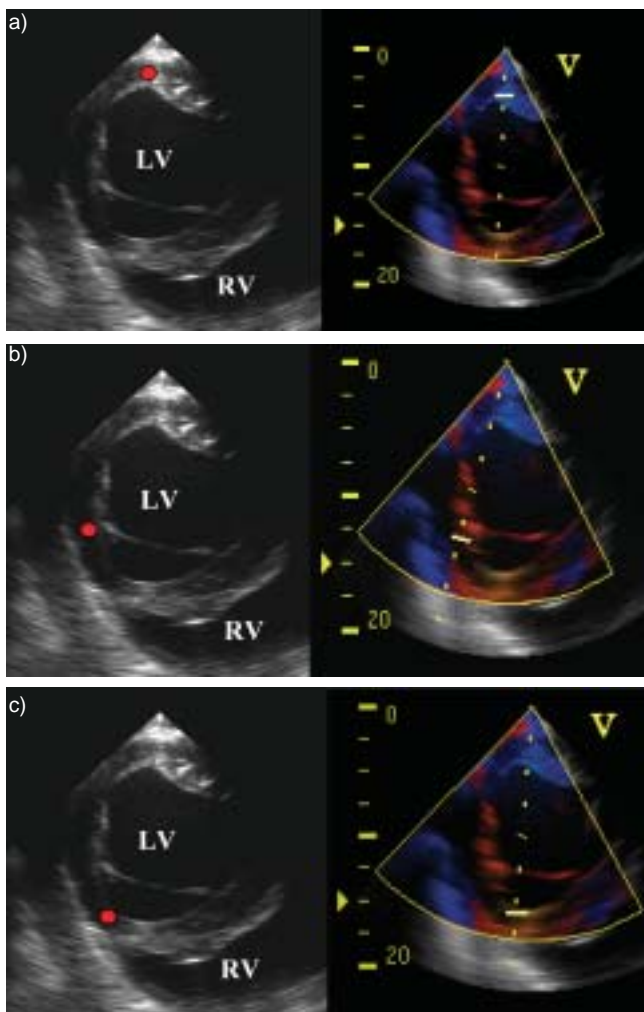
Two-dimensional and colour short-axis left parasternal images at the chordal level showing sampling sites for spectral (red dots) and colour (yellow bar) Doppler tissue imaging in a) left ventricular wall, b) caudal ventricular wall and c) right ventricular wall. LV = left ventricle; RV = right ventricle.
